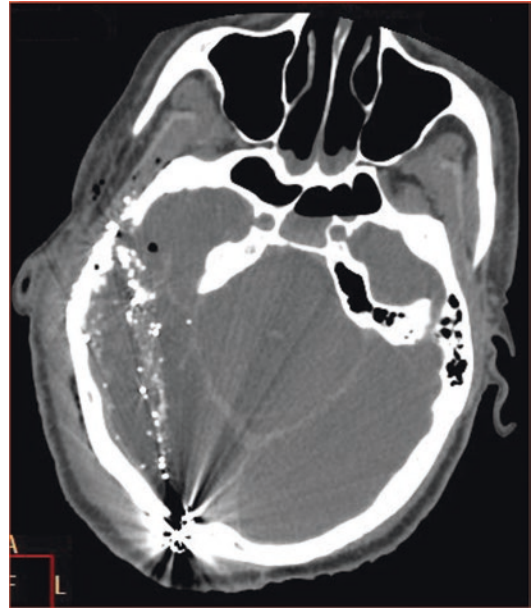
CT scan shows a bullet in the occipital bone and the fragments along the path of the bullet in a 45-year-old photograph who was accidentally gunshotted during a wedding
